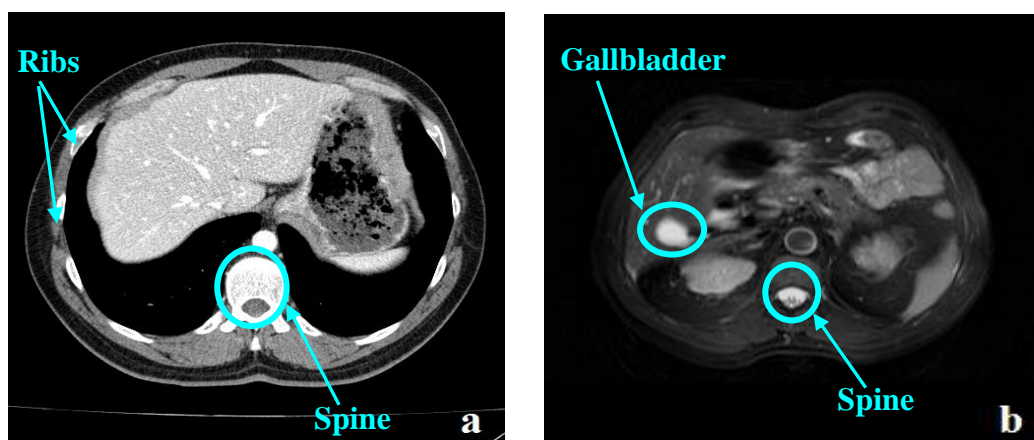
Example abdominal CT image that shows ribs and spine (a); Example abdominal SPIR image that shows gallbladder and spine (b)
